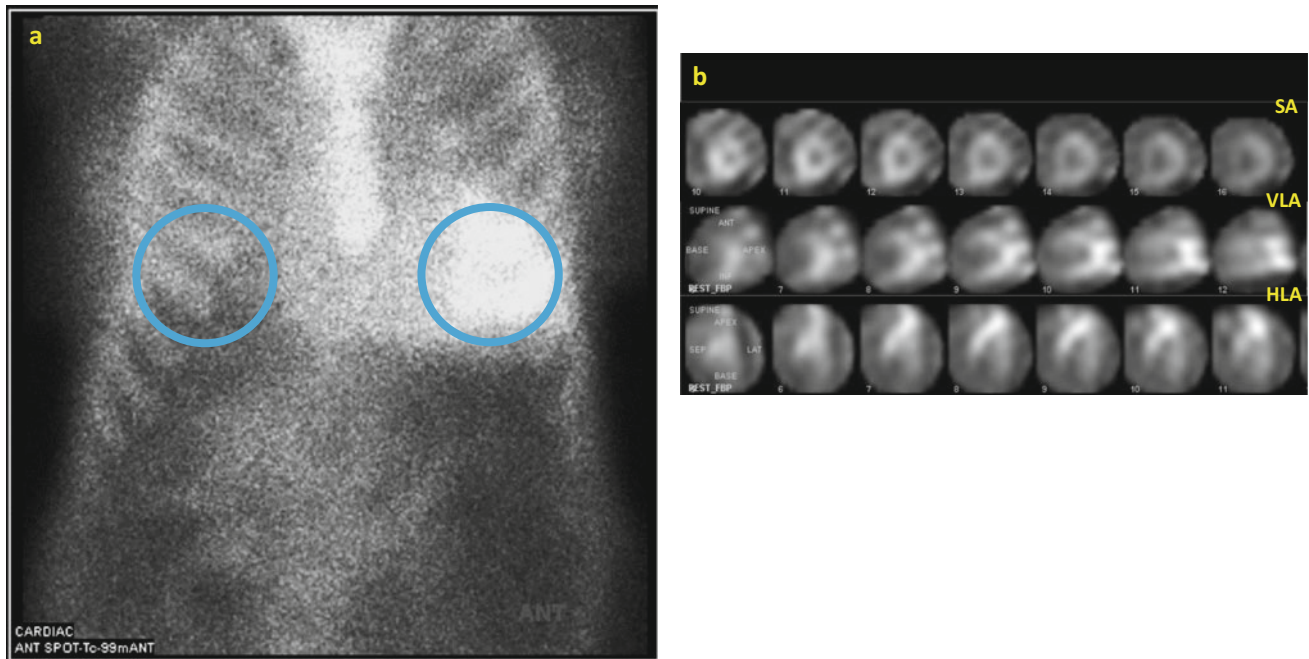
a Technetium-99 m pyrophosphate (Tc-99 m PYP) scintigraphy 1 h after radiotracer injection showing marked radiotracer uptake with a semiquantitative grade of 3 and a heart-to-contralateral lung (H/CL) ratio of 1.4. b SPECT images confirm myocardial PYP uptake. SA, short axis; VLA, vertical long axis; HLA, horizontal long axis
